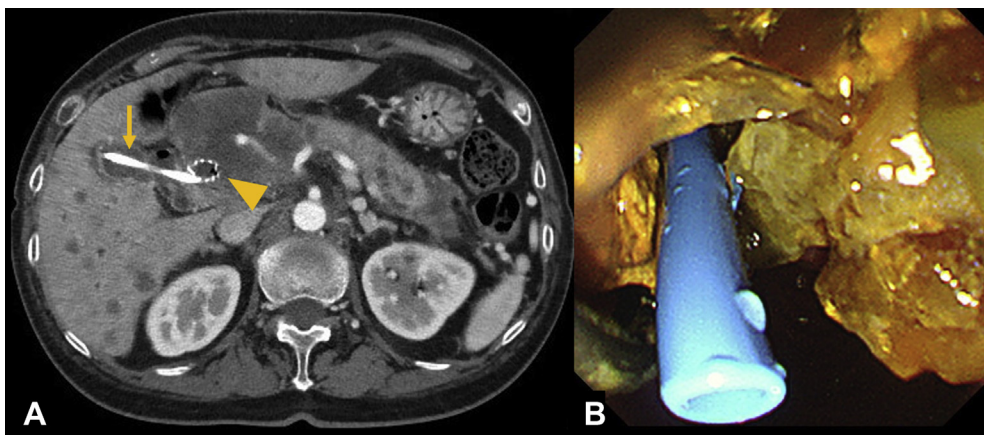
A, Abdominal CT shows a fully covered self-expandable metallic stent (SEMS, *arrowhead*) in the bile duct and a plastic stent (*arrow*) in the gallbladder. No biliary bleeding or pseudoaneurysm was observed. B, The endoscopic view shows SEMS occlusion by biliary sludge. We inserted an 8.5F plastic stent into the SEMS to resolve cholangitis.
